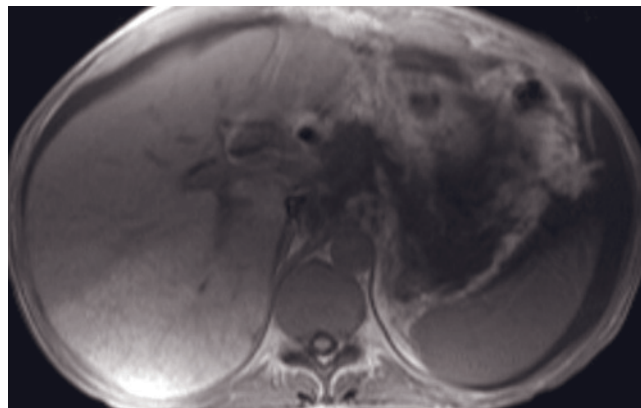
Focal fatty liver. CT (*a*), SGE (*b*), and out-of-phase SGE (*c*) images. A CT image acquired in a patient with breast cancer demonstrates a low-density lesion in the medial segment (arrow, *a*). The in-phase T1-weighted image (*b*) shows no lesion in this location, whereas on the out-of-phase image (*c*), signal drop occurs in the central region of the medial segment (arrow, *c*), which is diagnostic for focal fatty infiltration when combined with the information that enhancement was isointense on the hepatic arterial dominant-phase images.
